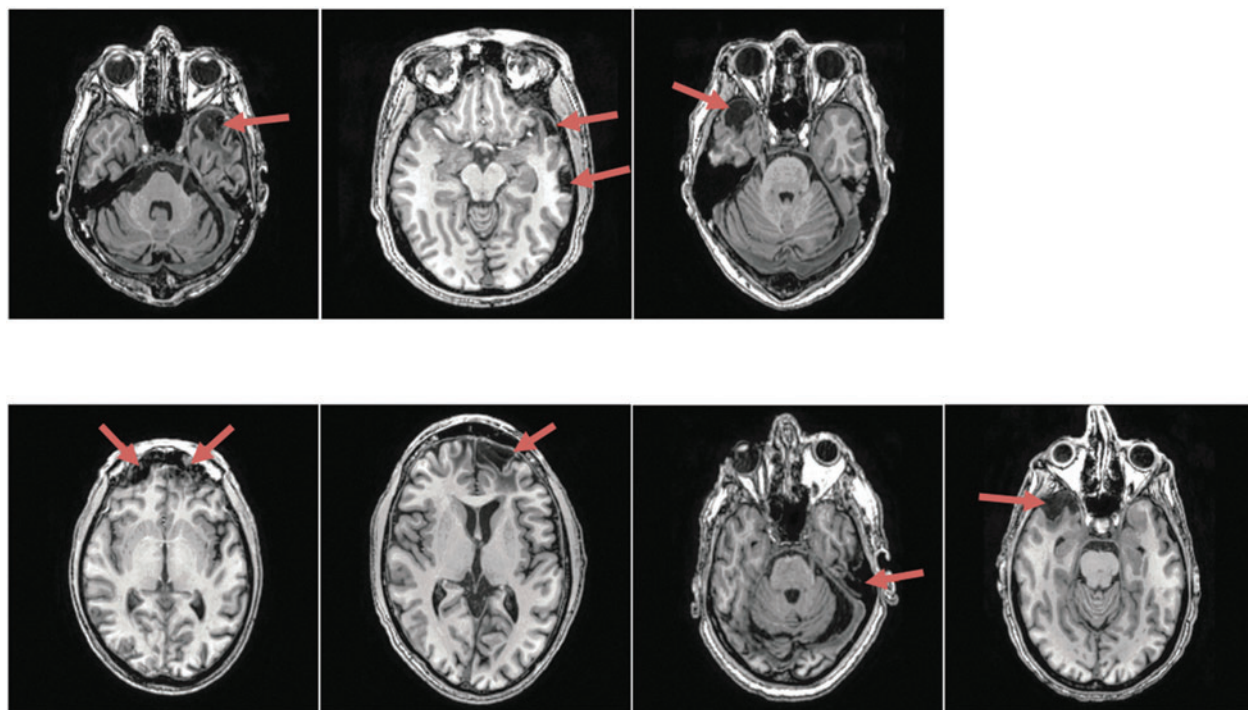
Representative case examples of traumatic brain injury visible on MRI. Top row: subjects who endorsed *no history* of head or face injury. Bottom row: subjects who endorsed a head or face injury without any loss of consciousness or confusion or memory loss. None of these participants reported a history of stroke. MRI, magnetic resonance imaging; TBI, traumatic brain injury.
